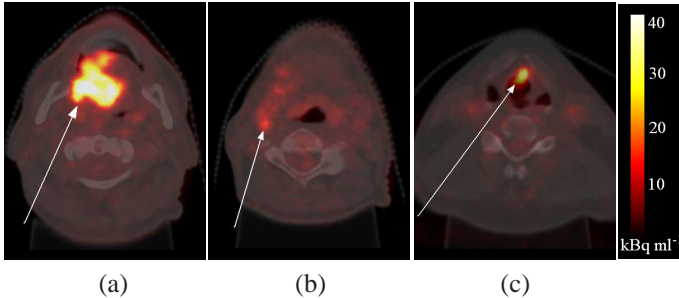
Axial neck slices of ^{18}F -FDG PET images overlain on simultaneous CT. (a) & (b) Oral cavity tumour & lymph node metastasis in patient 1 (c) Laryngeal tumour in patient 2.
